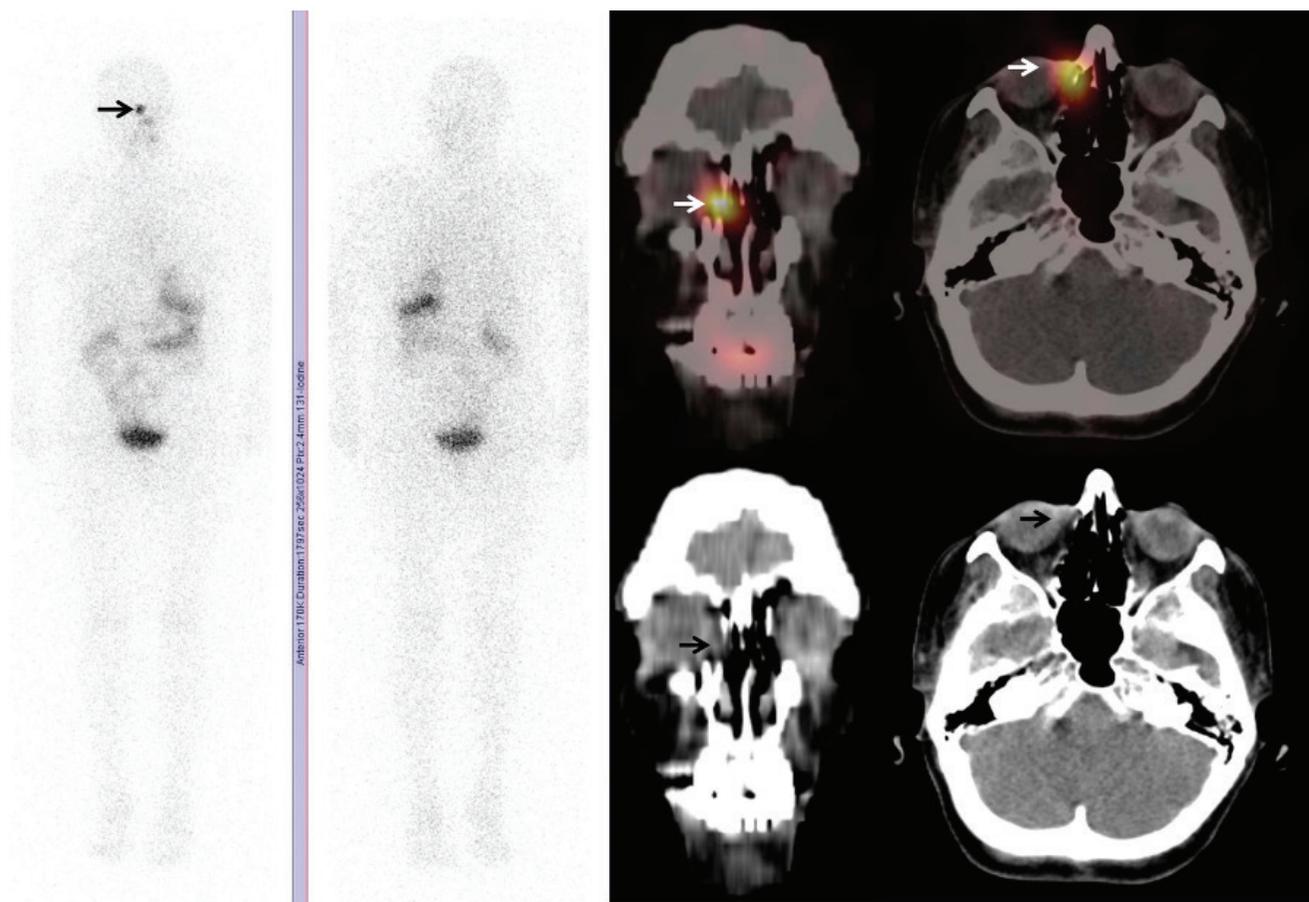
^{131}I whole body scan was performed on a 59-year-old female patient with papillary thyroid cancer (T3N1bM0), who was treated 5 years ago with total thyroidectomy followed by a single dose 150 mCi ^{131}I therapy. A planar ^{131}I whole body scan with single photon emission computed tomography/computed tomography (SPECT/CT) and spot neck pinhole images were obtained at the 48th hour after 5 mCi ^{131}I oral administration. At the time of imaging, stimulated thyroid-stimulating hormone level was 280 IU/mL, thyroglobulin (Tg) level was 0.20 ng/mL and anti-Tg antibody level was <0.9 IU/mL. The patient had no symptoms at the time of imaging. Planar ^{131}I whole body scan showed no significant radioactivity uptake that may be compatible with residual thyroid tissue or recurrent thyroid cancer, on the other hand a suspicious focus of intense increased uptake was noted at the right paranasal region, which mimics a metastatic lesion (arrow in planar images). SPECT/CT images revealed 7x4 mm sized soft tissue density lesion-demonstrating ^{131}I uptake, in the right infraorbital region next to the lateral wall of ethmoid sinus (arrows in fused SPECT/CT images) suggesting nasolacrimal duct obstruction (NLDO). Subsequently, an ophthalmologic examination and a diagnostic maxillofacial CT were performed to confirm the diagnosis. ^{131}I has been used for many years as a valuable treatment in thyroid diseases such as hyperthyroidism and differentiated thyroid carcinomas (1,2,3). NLDO is an uncommon complication of ^{131}I therapy, especially rarely occurs after a single dose of radioiodine treatment. Morgenstern et al. (4) reported that the cells of the lacrimal drainage system have the same Na/I symporters expressed by the cells of the thyroid gland and eventually the accumulation of ^{131}I in these cells results in radiation induced damage. Fibrosis and obstruction of lacrimal drainage system will cause ^{131}I uptake at the point of obstruction in whole body ^{131}I scan and that may be misinterpreted as a metastasis (5,6). SPECT/CT can be useful to discriminate these false positive findings of planar ^{131}I whole-body imaging, as in this study (7). Beside that early identification of these lesions may hasten the subsequent appropriate treatment of the patients and improve quality of life (8).
